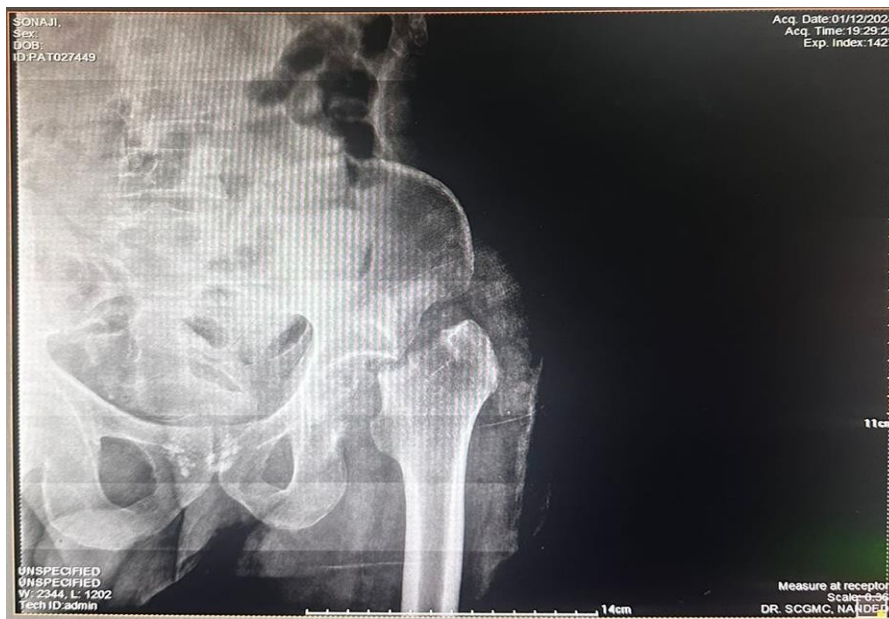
Post operative xray after femoral head excision
